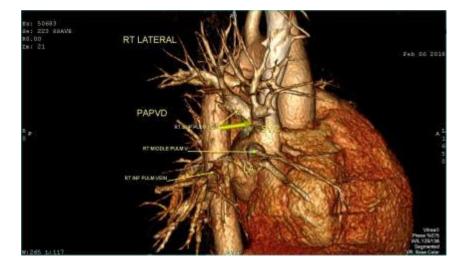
multi-slice CT, PAPVD
